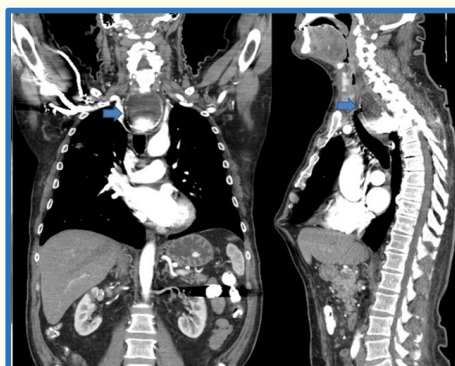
Cervical CT scan showing large Zenker's Diverticulum.
